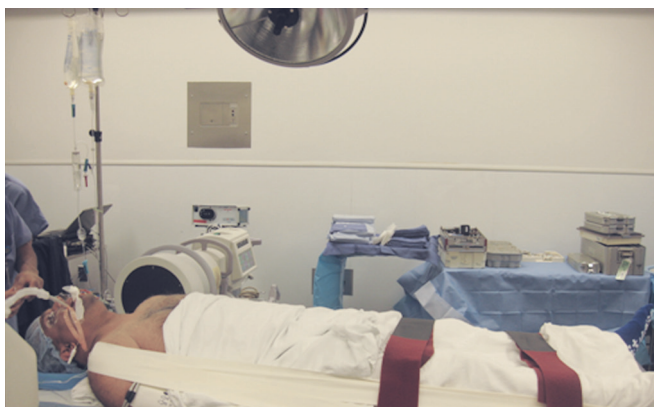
The final operative position has the patient secured supine in mild neck extension with a small roll placed transversely across both shoulders. The head is toward anesthesia; the fluoroscopy machine is positioned transversely at the level of the cervical spine in preparation for localization. The shoulders are gently retracted caudally and are taped in place for better radiographic exposure of lower cervical levels.
